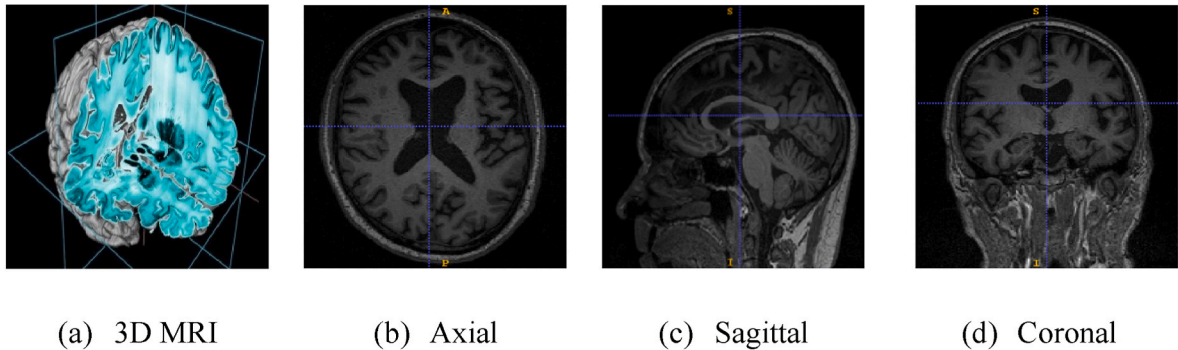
Axial, Coronal and Sagittal views of a 3D MRI image.
